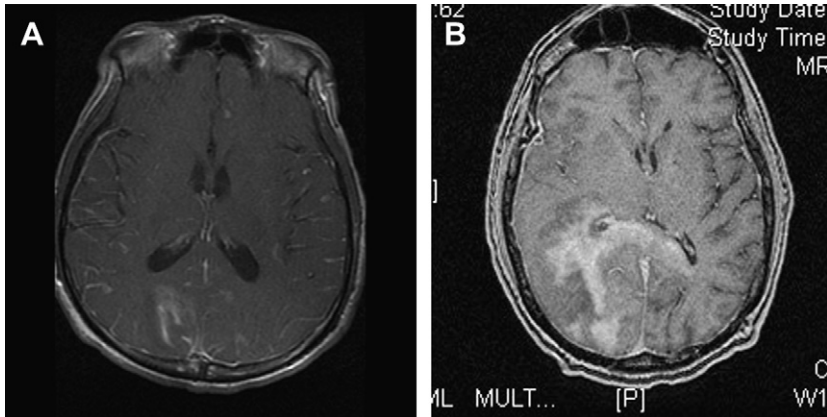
Two patterns of immune reconstitution inflammatory syndrome (IRIS). (A) Gadolinium-enhanced T1-weighted MRI that shows intense leptomeningeal enhancement in a patient recently treated for cryptococcal meningitis who has had rapid rise in CD4 count on antiretroviral therapy and presents with seizures and marked rise in intracranial pressure. (B) Gadolinium-enhanced T1-weighted MRI that shows a different HIV-positive patient newly on antiretroviral therapy presenting with hemianopia and a mass lesion resembling high-grade tumor owing to PML with IRIS.
